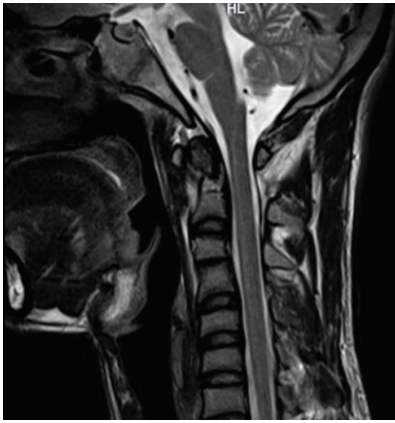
MRI showing Type II odontoid fracture
